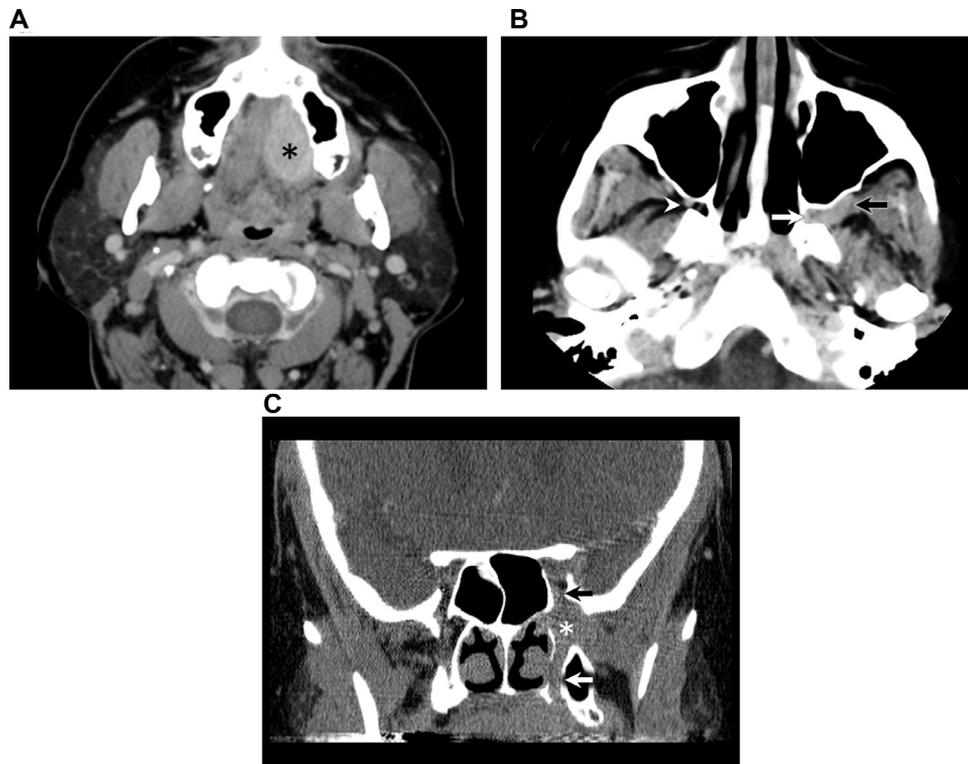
Perineural spread of tumor from hard palate adenoid cystic carcinoma infiltrates the pterygopalatine fossa. (A) Axial contrast-enhanced CT. There is an enhancing mass arising from the left hard palate (black asterisk). (B) Axial contrast-enhanced CT. Perineural tumor spread via the left greater palatine obliterates the fat of the left pterygopalatine fossa (white arrow), with extension through the left pterygomaxillary fissure effacing the adjacent left retromaxillary fat pad (black arrow). Compare this to the normal appearing right pterygopalatine fossa (white arrowhead). (C) Coronal reformat contrast-enhanced CT. Extensive perineural spread of tumor widens the left great palatine foramen (white arrow), fills the left pterygopalatine fossa (white asterisk) and extends superiorly into the left inferior orbital fissure (black arrow) where the fat planes are effaced on CT. Surgical pathology confirmed adenoid cystic carcinoma.
